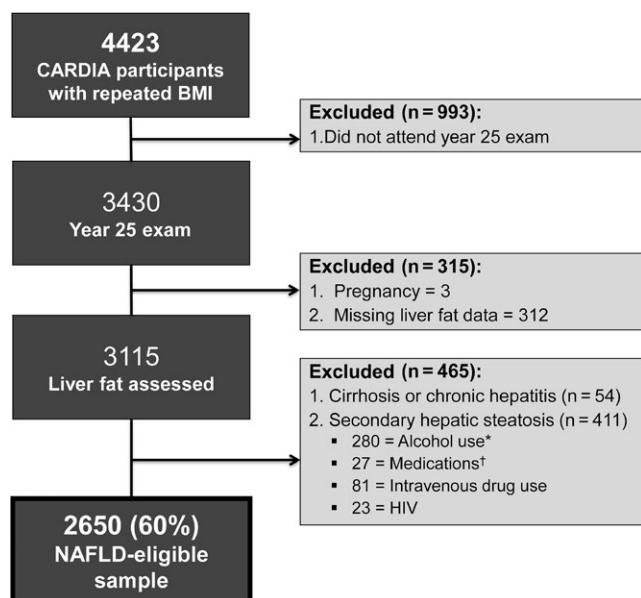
Study population. Abbreviations: CT, computed tomography; HIV, human immunodeficiency virus. *Alcohol use was defined as ≥ 7 drinks/wk in women, ≥ 14 drinks/wk in men. †Medications = valproic acid, methotrexate, tamoxifen, steroids and amiodarone
